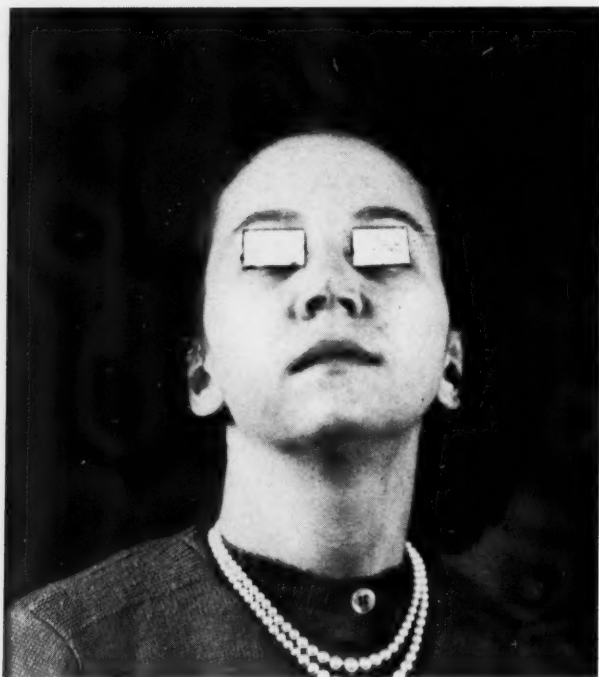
D. S., age 32: Showing appearance of tip of nose two years after excision of basal cell ulcer (1×1.25 cm.) from tip of nose. Full-thickness skin graft from postauricular region was immediately applied. (The lesion resulted from repeated roentgen-ray treatments for acne).
